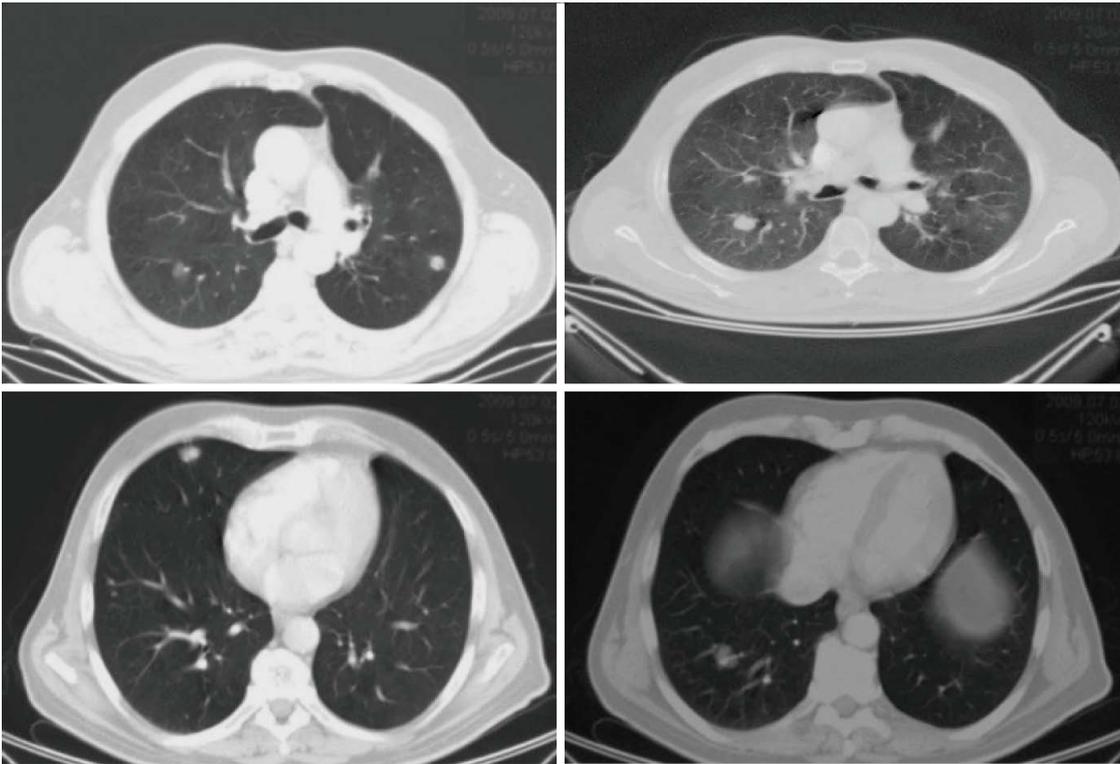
Thorax computed tomography-scan after 8 cycles of treatment. Note stabilization of the disease according to RECIST criteria (June 2009).
